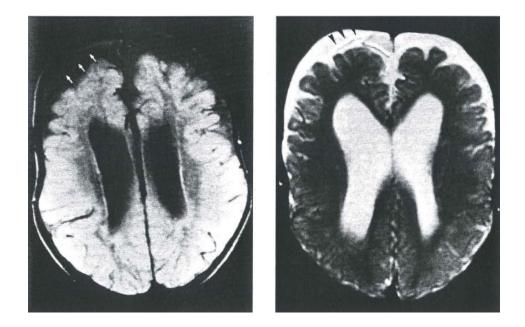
shows two images from MRI scans taken when the patients were 16 months old. The image on the left (Case 1) uses a technique called proton weighting, while the image on the right (Case 2) uses T2 weighting. These images reveal that the fluid collecting outside the brain appears similar in density to cerebrospinal fluid, and there are areas within the fluid where blood vessels are visible (indicated by arrowheads and arrows).
